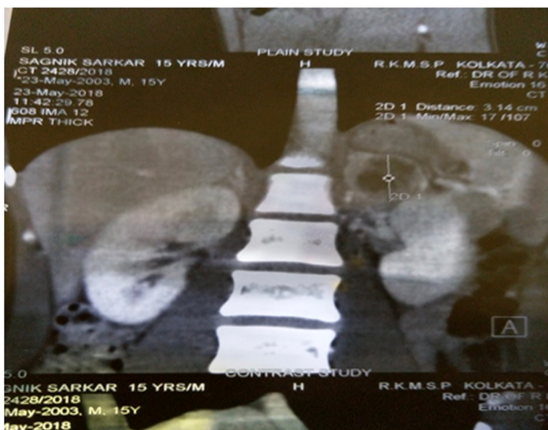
CT scan reveals left adrenal SOLI-131 (Metaiodobenzylguanidine)
